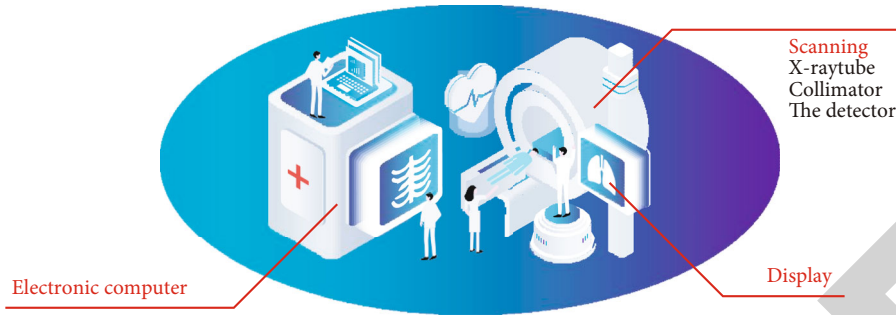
Principle of CT imaging.
